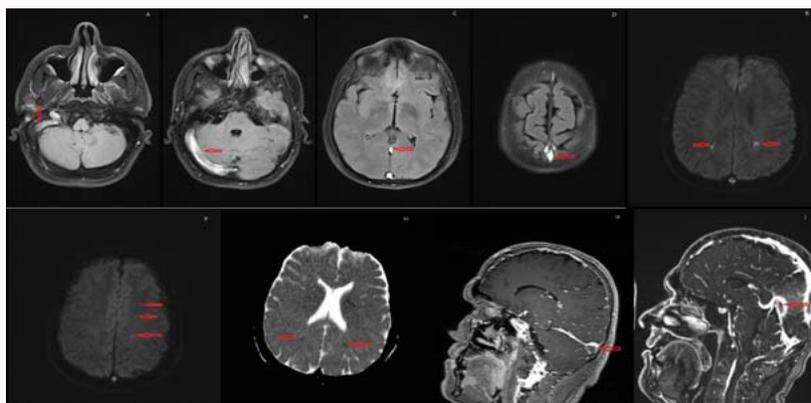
In the first case, brain MRI revealed in FLAIR sequence an appearance compatible with hyperintense thrombus in the right sigmoid sinus (A), right transverse sinus (B), straight sinus (C), and superior sagittal sinus (D). Bilateral watershed infarct areas with marked diffusion restriction were observed on DWI on the left (E-G). Thrombus material compatible with CVST was observed in contrast-enhanced MRV (H,I).
